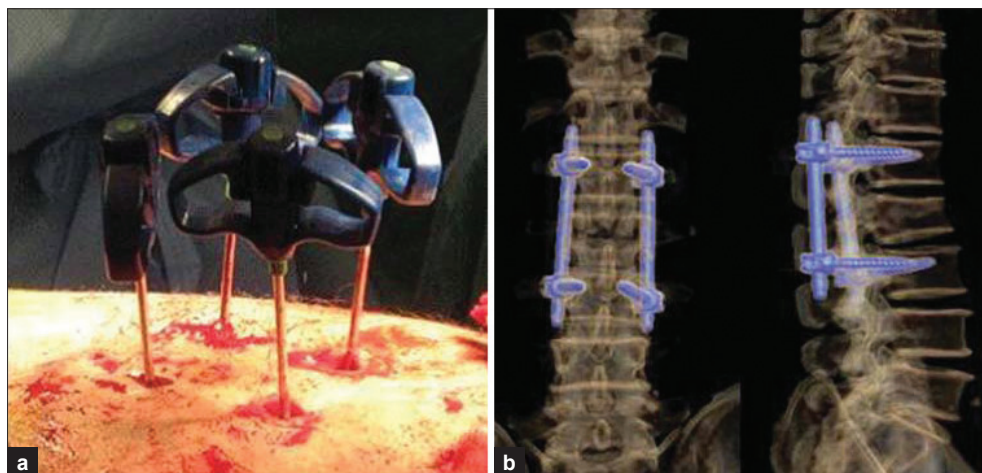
(a) Intraoperative images showing skin incision and simultaneous placement of introducer (b) reconstructed computed tomography showing pedicle screw fixation *in situ*
